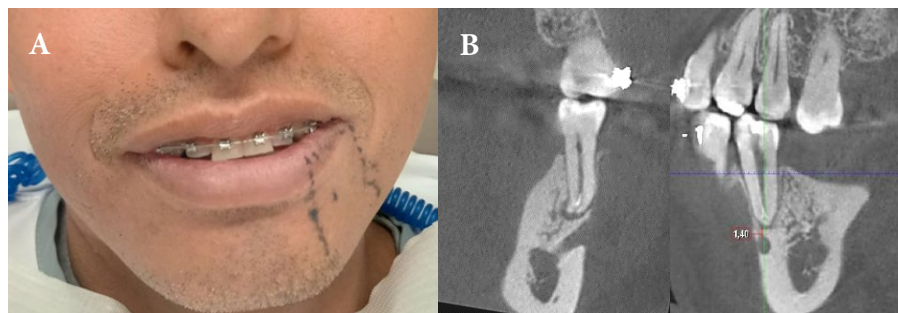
A) The skin in the region of the left mental nerve distribution presented with paresthesia; B) CBCT images of the initial appointment
